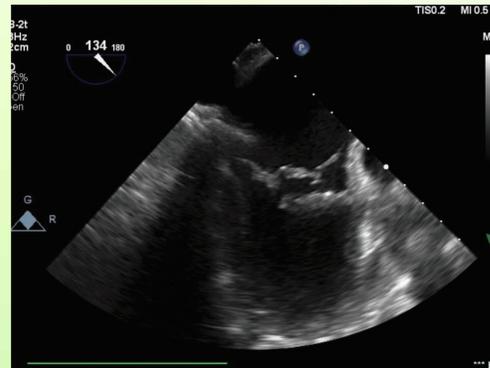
Transesophageal echocardiogram with mid-esophageal long axis view demonstrating mitral valve P2 segment prolapse with flail due to a ruptured chordae tendinae.
